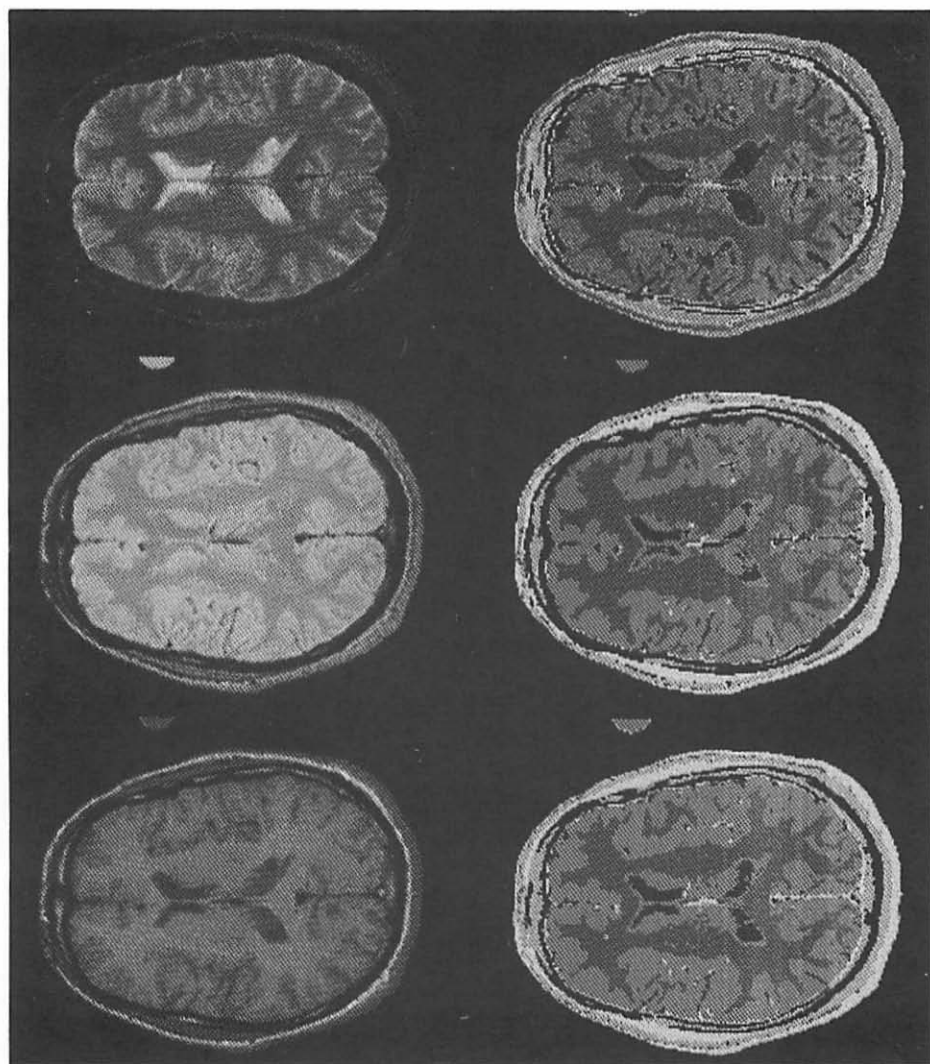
Segmentations obtained for SE sequences on General Electric MRI system
